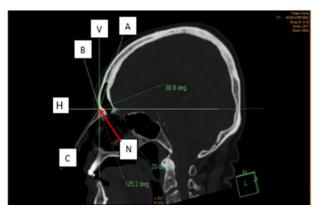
CT image showing the measurements of angular forehead
